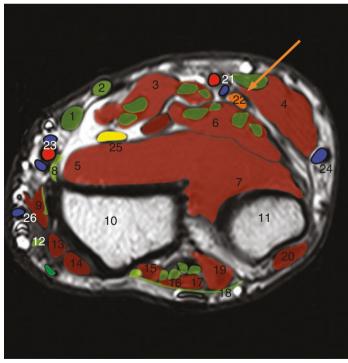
MRI scans in the wrist through ulnar nerve
